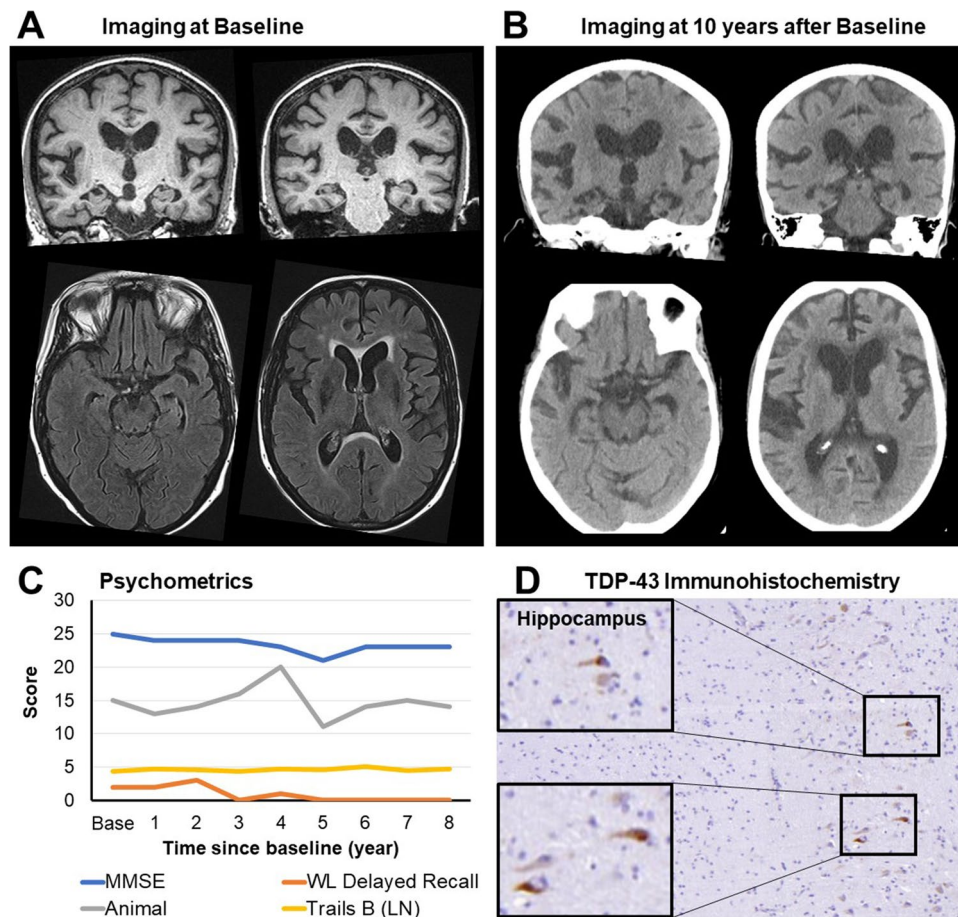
Example clinical vignette of a patient with LATE. A 78-year-old woman presents with several years of subjective memory loss and was clinically diagnosed with AD. A At baseline, T1-weighted coronal MRI (top) shows some volume loss in the bilateral hippocampi and medial temporal lobes, with axial FLAIR sequence scan depicting periventricular white matter hyperintensities corresponding to small vessel ischemia. B Ten years after baseline scan, coronal (top) computed tomography (CT) shows mild interval change of limbic structures, with some ventricular dilatation and widening of the lateral fissures compared to prior studies. Small vessel disease is redemonstrated as periventricular hypodensities on axial CT
